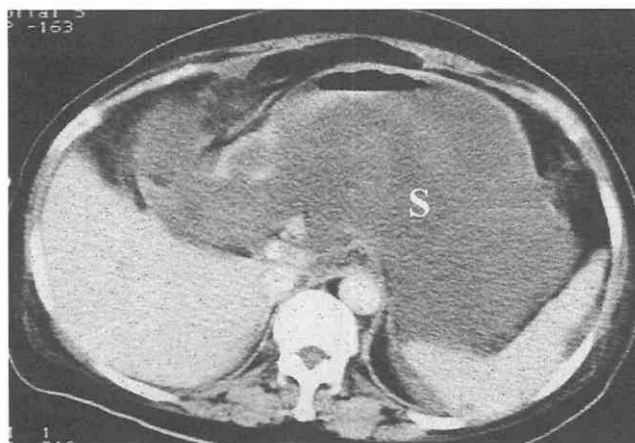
Corrosive gastritis after acid ingestion, with nearly complete loss of posterior wall of the stomach (S), as seen on this CT scan.
